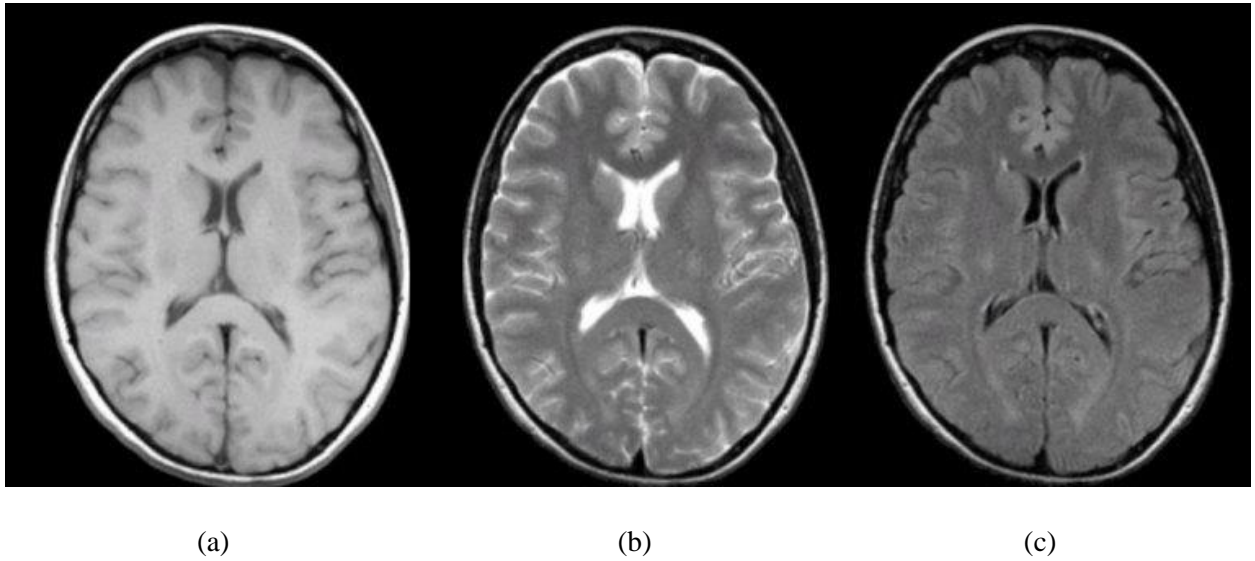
(a) T1 – Weighted, (b) T2 – Weighted, (c) FLAIR (Right)
